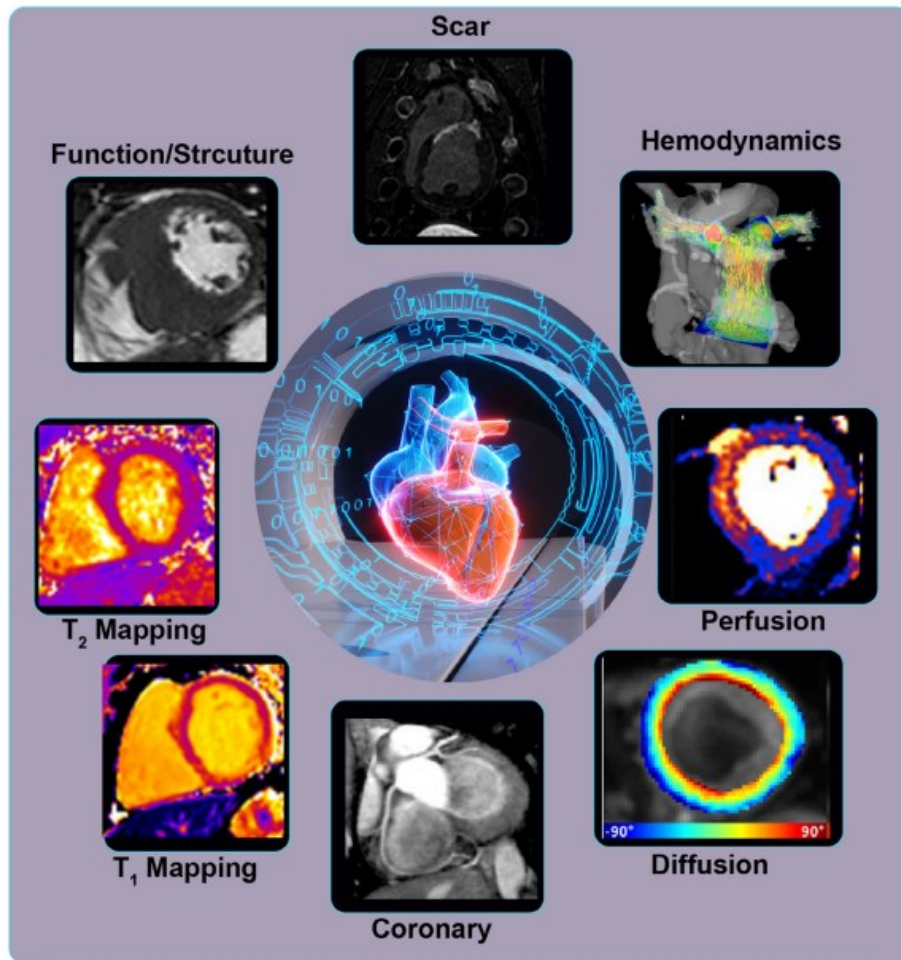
Summary of the functions of CMR: Cardiac MR imaging provides a comprehensive assessment of the structure, function, perfusion, viability, hemodynamic, microstructure, and myocardial mapping via T1, T2, and T2\* [6]
